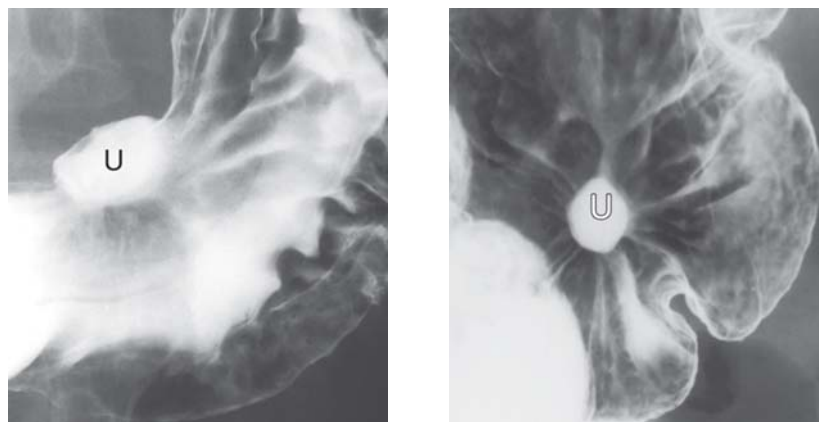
X-ray: gastric ulcers (barium collects in ulcer crater)*
